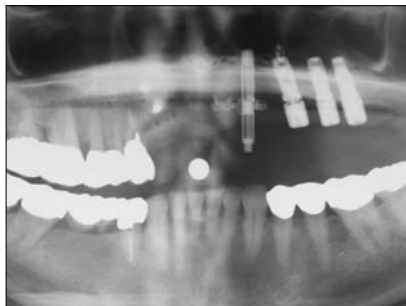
Radiograph showing the inadequate bone for implant support.
